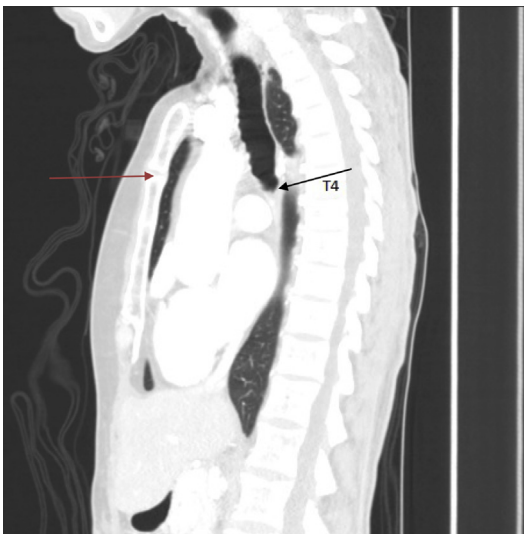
Coronal view of the computed tomographic (CT) scan of a 40-year-old woman. Note the posterior deflection of the intrathoracic trachea. Note also that the carina (*black arrow*) lies just below the level of the angle of Louis (*red arrow*), the site of insertion of the cartilage of the second rib.
